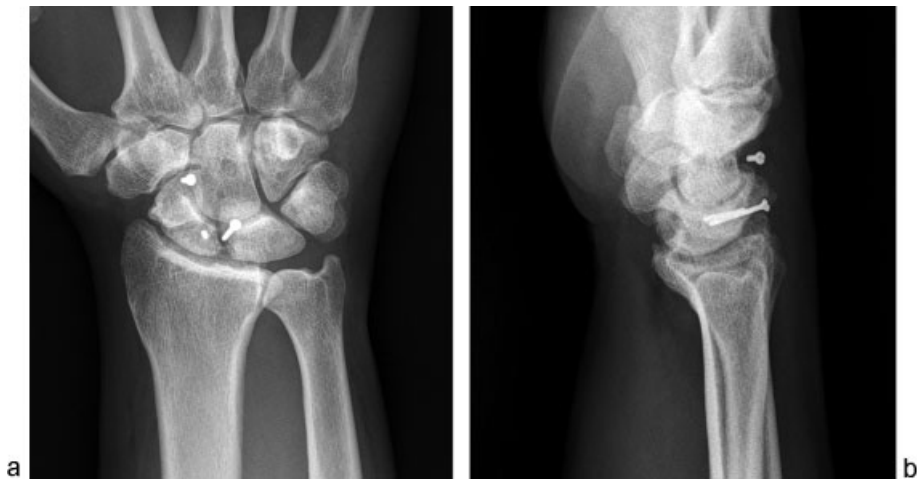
(a,b) AP and lateral radiographs of wrist 6, 81 months after the original procedure, demonstrating screw breakage and migration and development of SLAC changes. This patient went onto a scaphoidectomy and four-corner fusion.
